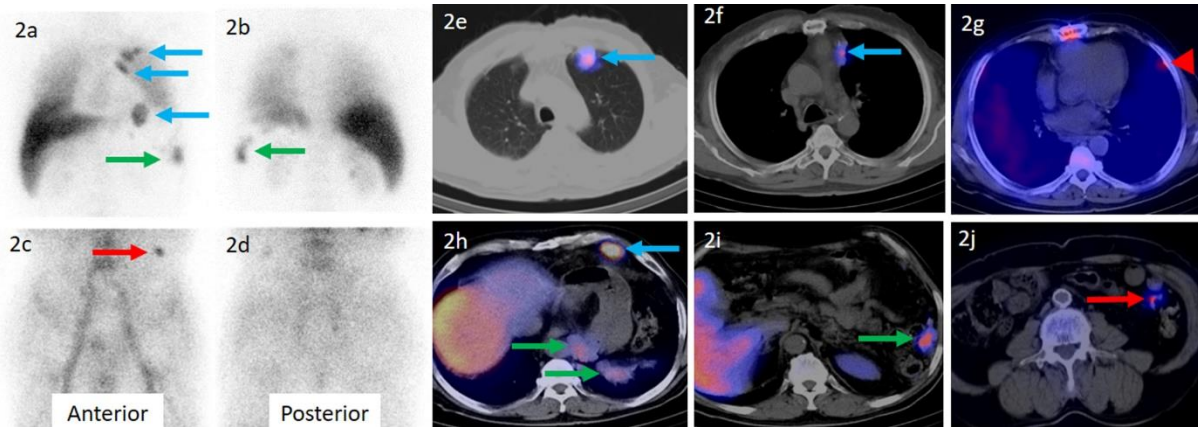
A 71-year-old male with a history of rectal cancer and pulmonary metastases underwent technetium-99m-denatured red blood cell (^{99m}Tc]Tc-DRBC) scintigraphy to confirm the presence of splenic tissue. Planar thoracic (anterior: 2a, posterior: 2b) and abdominal (anterior: 2c, posterior: 2d) images, as well as fused hybrid single-photon emission computed tomography/computed tomography (SPECT/CT) views, show multiple foci of increased uptake in the thoracic (blue arrows) and abdominal (green arrows) regions, which are compatible with lesions demonstrated in ^{18}F FDG PET/CT. Additional foci of uptake are demonstrated in the left pleura (red arrowhead) and left upper abdominal quadrant, attached to the bowels (red arrow)
